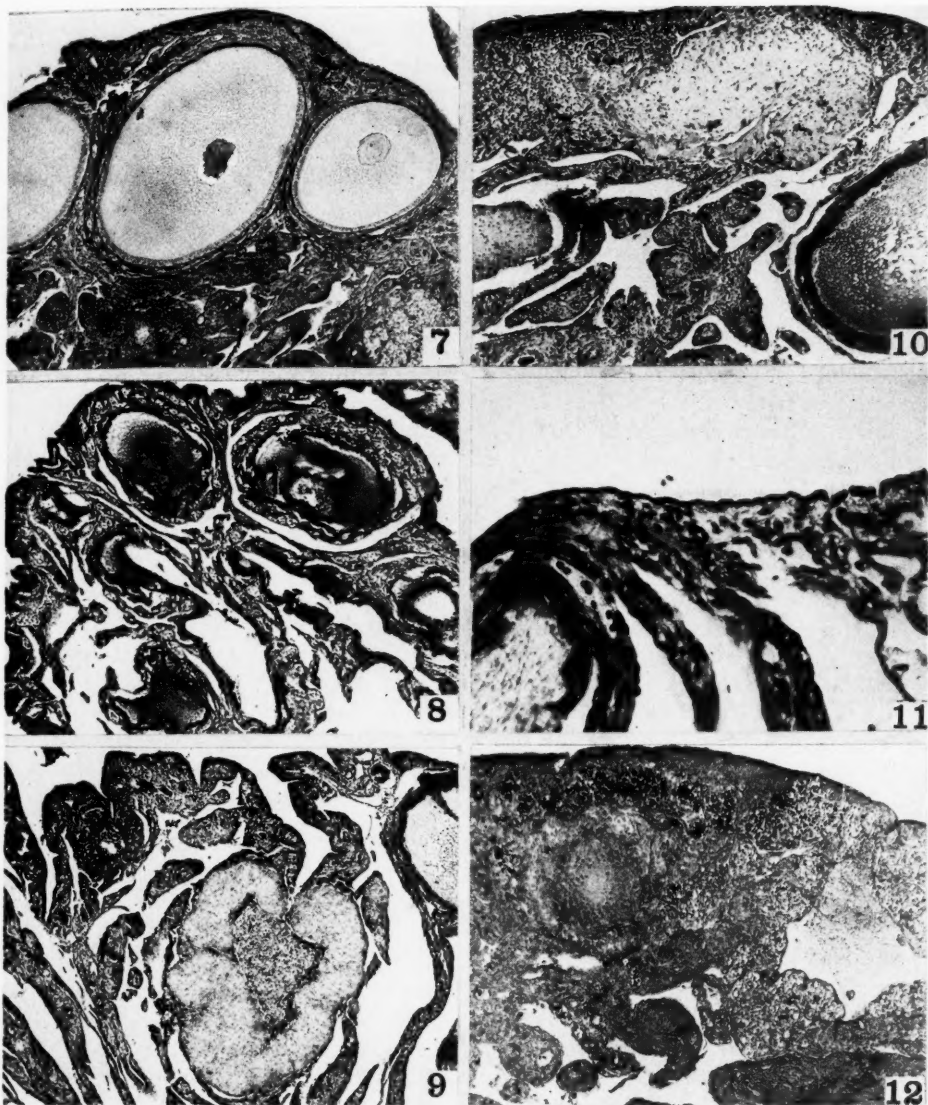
Section of an ovary showing initial injury caused by 400 r of x-rays. Note the shrinkage of the nucleus and the scalloping of the nuclear membrane ($\times 83$).
